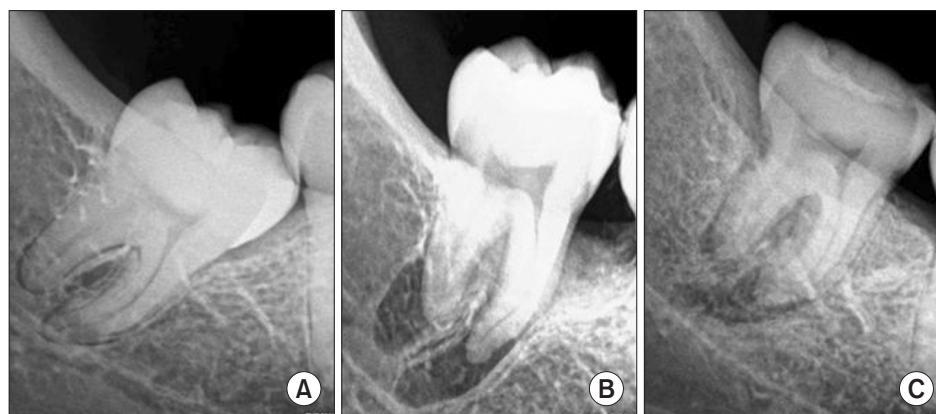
A. Intraoral periapical radiograph showing the partially impacted mesioangular third molar (preoperative). B. Intraoral periapical radiograph showing the upright third molar with normal occlusion (immediate postoperative). C. Intraoral periapical radiograph showing the healed periapical region in relation to the third molar (at the 6-month follow-up).
